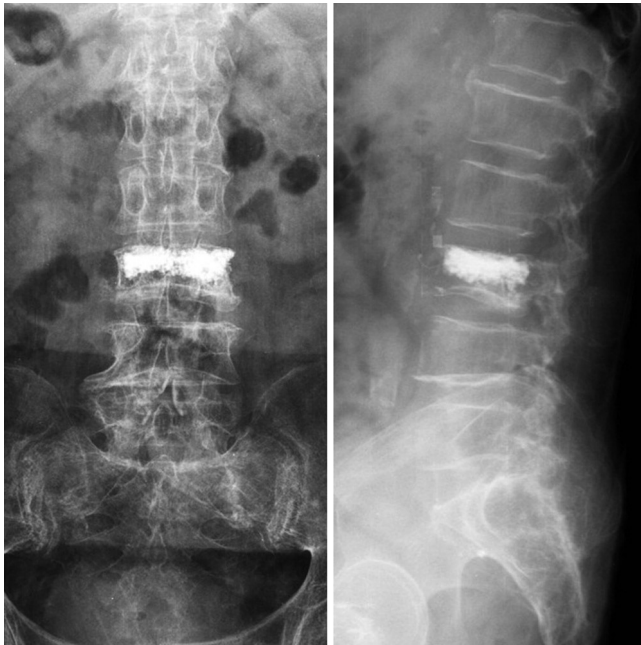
Initial anteroposterior and lateral radiographs of the lumbar spine demonstrate L3 vertebroplasty without definite bony lesion.
